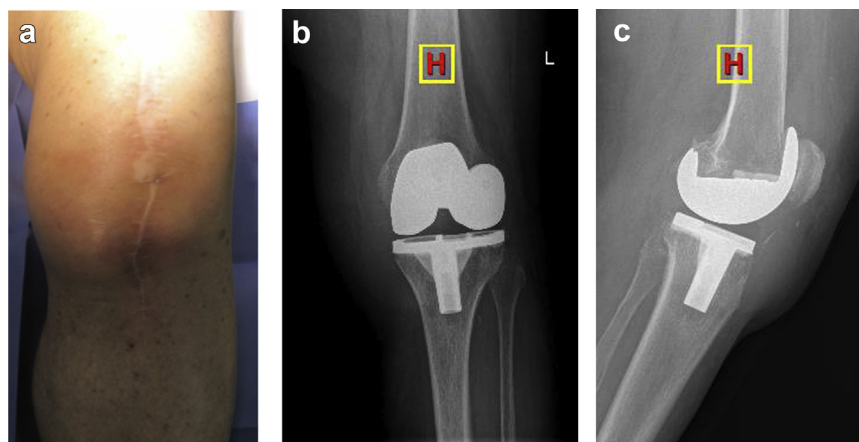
Clinical photograph (a) shows the knee incision site with effusion, tenderness, and erythematous. Anteroposterior (b) and lateral (c) radiographs of the left knee showing no femoral or tibial component loosening.
